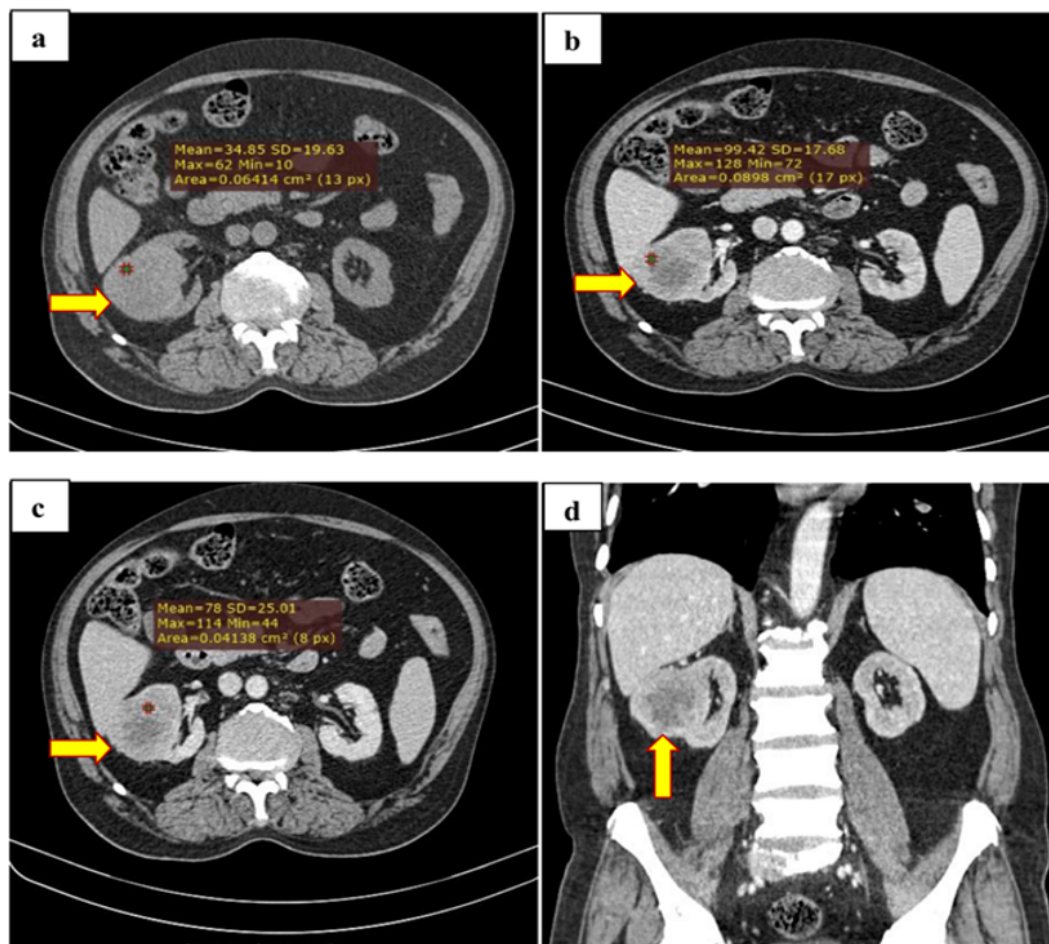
Case of renal cell carcinoma of ball type lesion in middle aged male patient a) Axial unenhanced CT showing iso to hyperdense mass. (b) and (c) CMP & NP showing heterogenous enhancement. (d) Coronal MPR image is helpful in evaluation of contour, location & extent.
